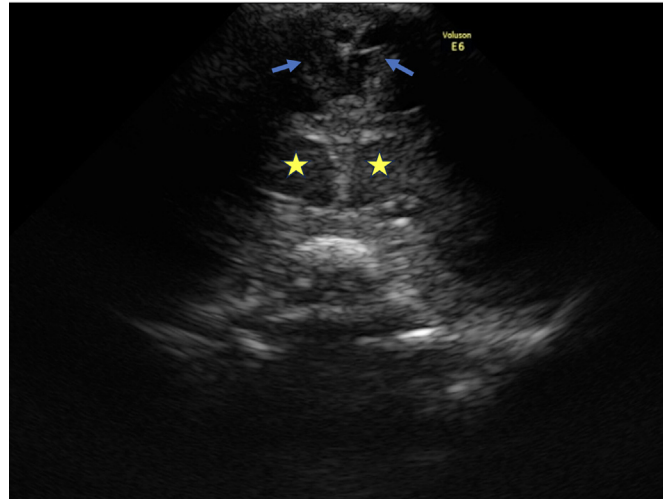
Transfontanellar ultrasound scan with coronal section, revealing brain atrophy in frontal portion (Blue arrows) with ventriculomegaly (Yellow stars). (The challenging acoustic window due to the overriding of cranial bones is evident, emphasizing the need for complementary imaging techniques for accurate characterization.).
